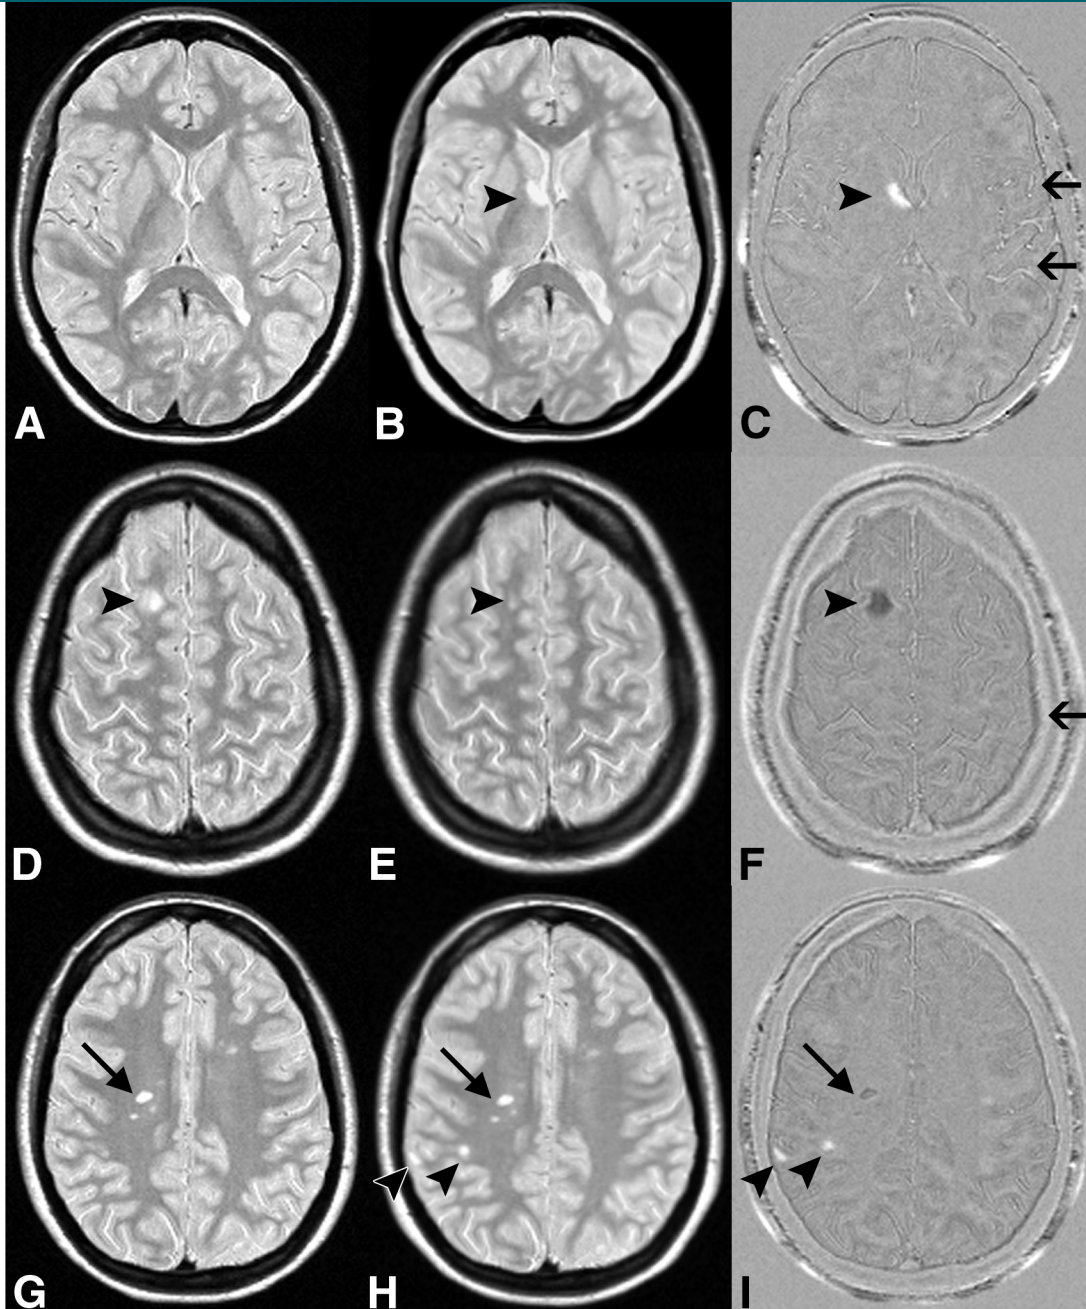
MS activity on, *A, D, G*, halfway-registered baseline PD-weighted MR images; *B, E, H*, halfway-registered follow-up PD-weighted images; and *C, F, I*, subtraction images. *B, C*, Arrowheads = new lesion (positive activity) shown as hyperintensity on *C*. Arrows = flow artifacts. *D, E, F*, Arrowheads = shrunken lesion (negative activity) shown as hypointensity on *F*. Arrow = residual registration artifact. *G, H, I*, Arrowheads = new lesions, one of which is juxtacortically located and easily missed on *H* but is clearly visible on *I*. Arrows = false-positive negative activity. Lesion was visible on both *G* and *H* and did not decrease in size.
